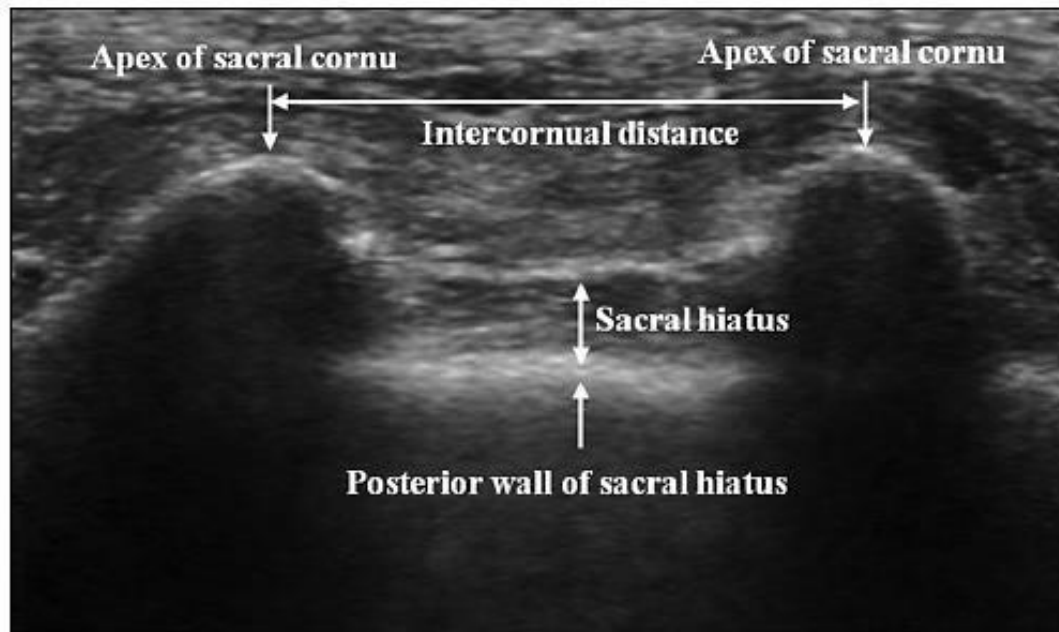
Ultrasonographic appearance of sacral hiatus (Park, Kwon, & Cho, 2015)
